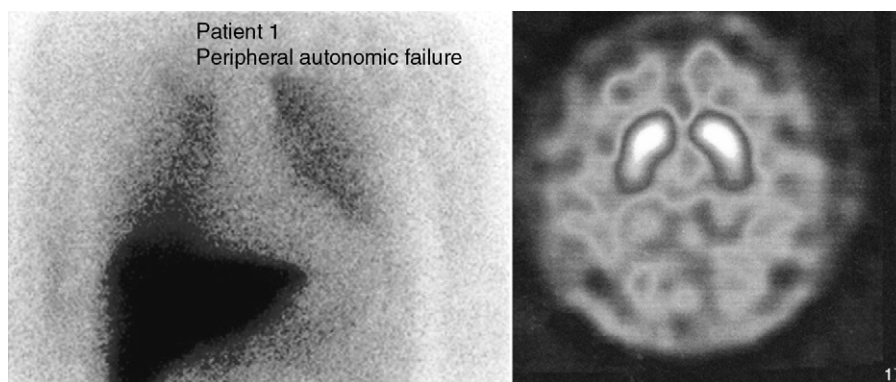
Nuclear medicine tests in the first case. The left part of the cardiac-MIBG SPECT shows a significantly low cardiac uptake. The right 123-I-FP-CIT SPECT (DAT-SCAN) is normal.
